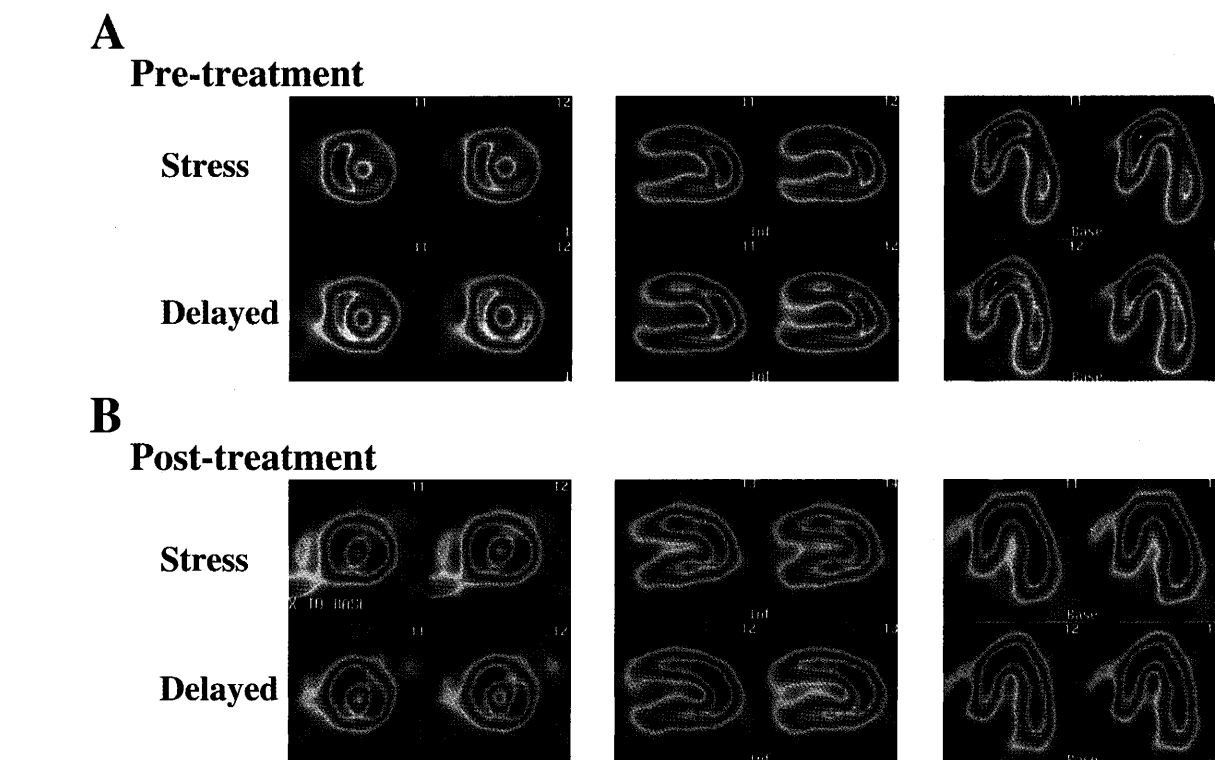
Thallium-201 (^{201}Tl) single photon emission computed tomography imaging of a 55-year-old man with intractable angina pectoris treated with granulocyte colony-stimulating factor (G-CSF) who has 3 vessel coronary heart disease in spite of several percutaneous coronary intervention and a low ejection fraction of 25% and chronic renal failure. Note the defect of ^{201}Tl in the anterolateral wall before G-CSF treatment and the improvement after the treatment.
